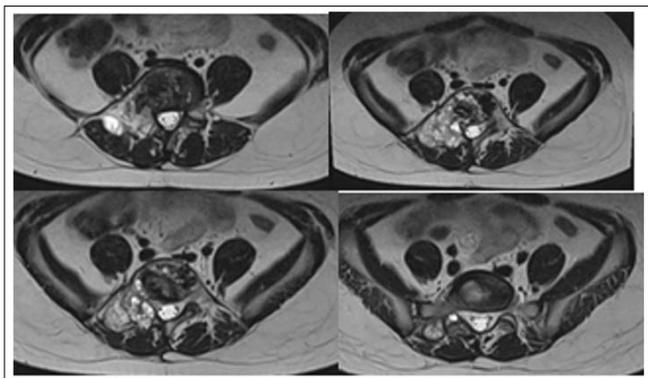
The Follow-Up MRI 6 Months after the Completion of IMRT/ November 2023
